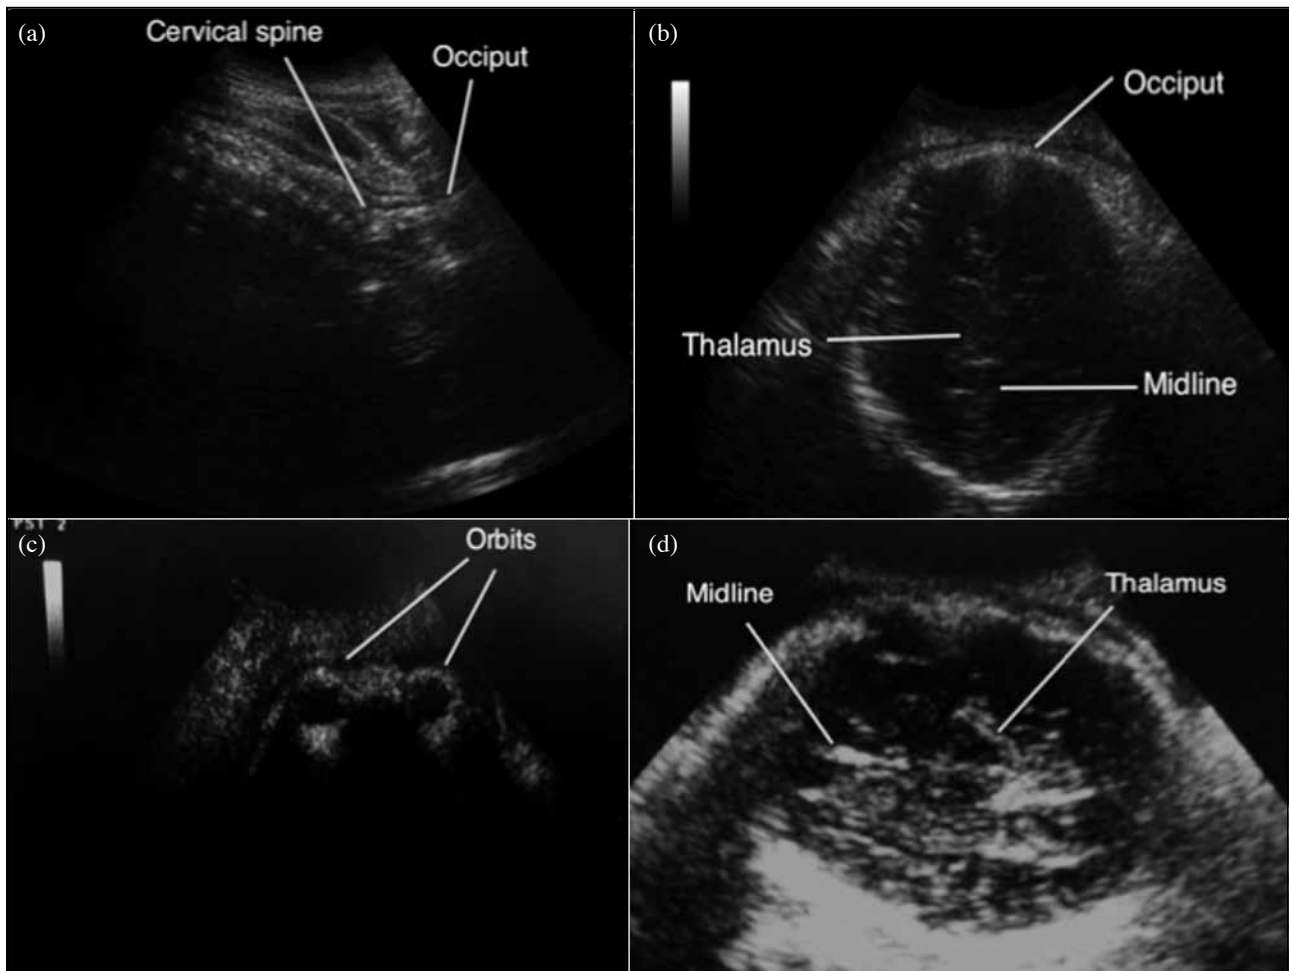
(a) Sagittal view of transabdominal ultrasound in a fetus with occipito-anterior position. (b) Transverse view of transabdominal ultrasound in the same fetus, obtained by turning the probe at 90 degrees. (c) Transverse view of a fetus in occipito-posterior position with both orbits used as landmarks. (d) Transverse view of a fetus in occipito-transverse position with midline cerebral echo, fetal thalami as landmarks
